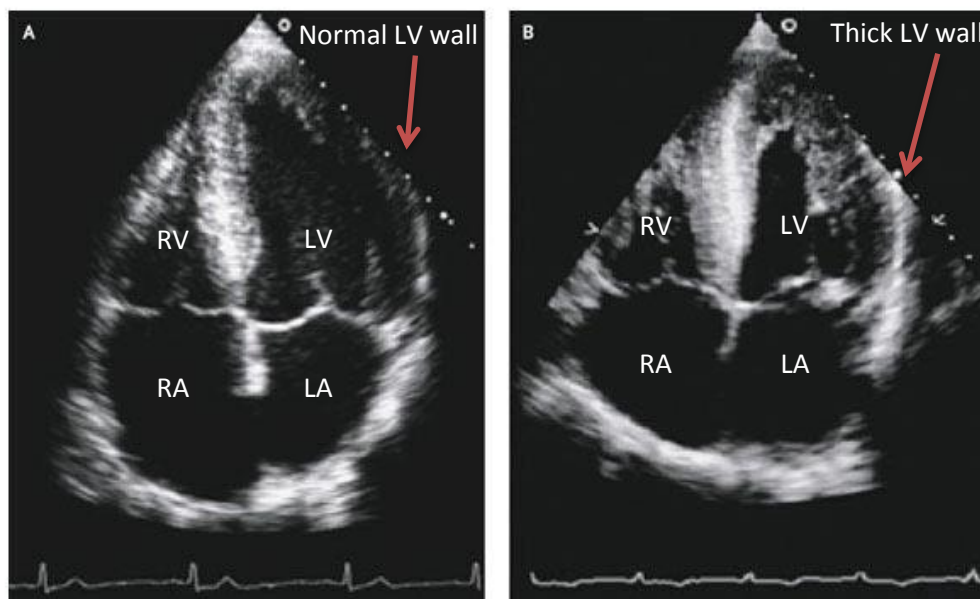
Echocardiographic images showing a person with a normal functioning heart (A) and a patient with diastolic heart failure (B). The patient with heart failure has a thick LV wall (Gaasch et al., 2004). RV=Right Ventricle, RA=Right Atrium, LV=Left Ventricle and LA=Left Atrium.
